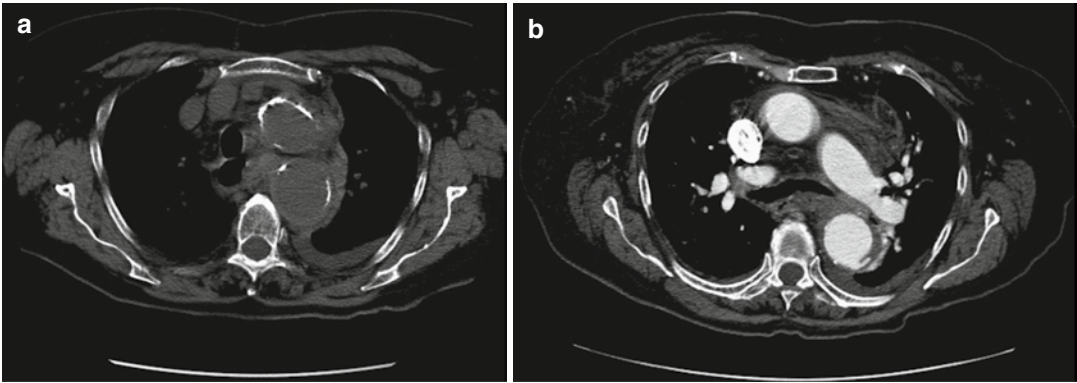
Unenhanced (a) and enhanced (b) axial CT scan of a patient with ruptured aortic aneurysm. Unenhanced image (a) shows discontinuity in wall calcifications, high-attenuation hematoma, and draping of the posterior
